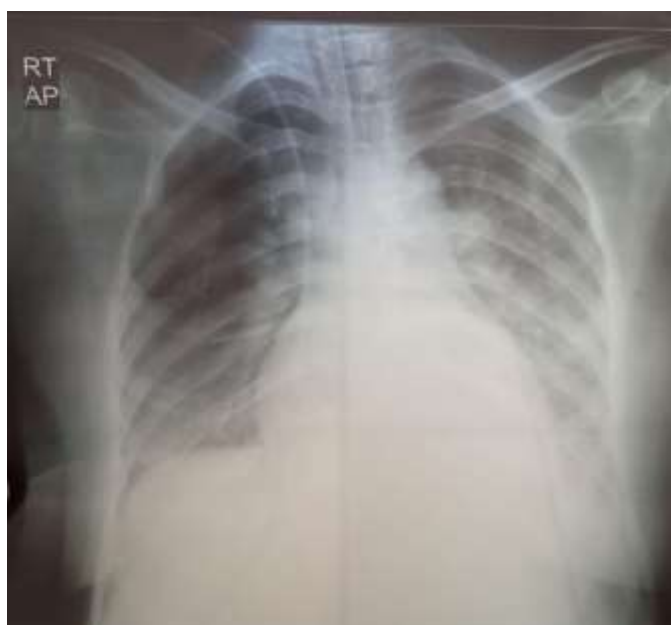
X-ray chest of female patient 22 years old with bilateral lower lobe consolidation
